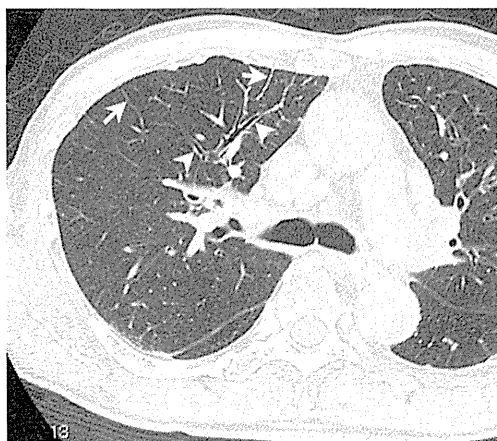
Acute transformation (acute type) in a 69-year-old male patient with smouldering type ATLL, 10 days after the onset of fever. Transverse CT image (1-mm thickness) at the level of the tracheal carina shows interlobular septal thickening (*arrows*) and bronchial wall thickening (*arrowheads*)
